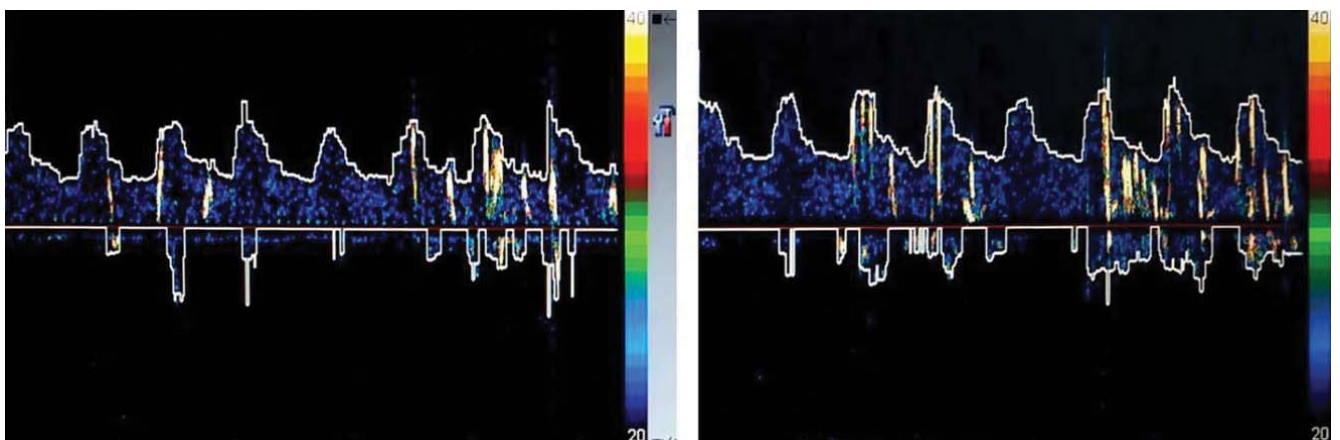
Transcranial Doppler image showing frequent bilateral microembolic signals.
